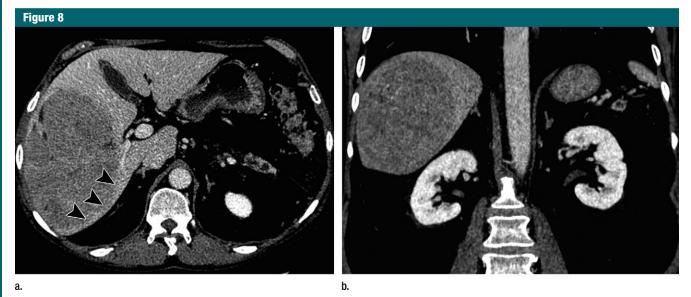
CT images in a 59-year-old man with large hepatocellular carcinoma in the right liver. (a) Axial contrast-enhanced image in the portal venous phase shows hypoattenuation on the portal venous phase. On arterial phase images (not shown), the tumor was slightly hypervascular. Liver parenchyma is embedded in the periphery of the tumor (arrowheads). (b) Coronal contrast-enhanced image at the portal venous phase shows the intrahepatic location. Note absence of displacement of the right kidney.
